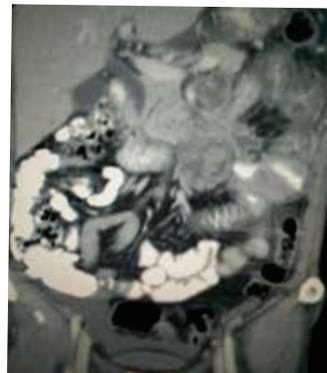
CT scan showing lymphnode metastasis
